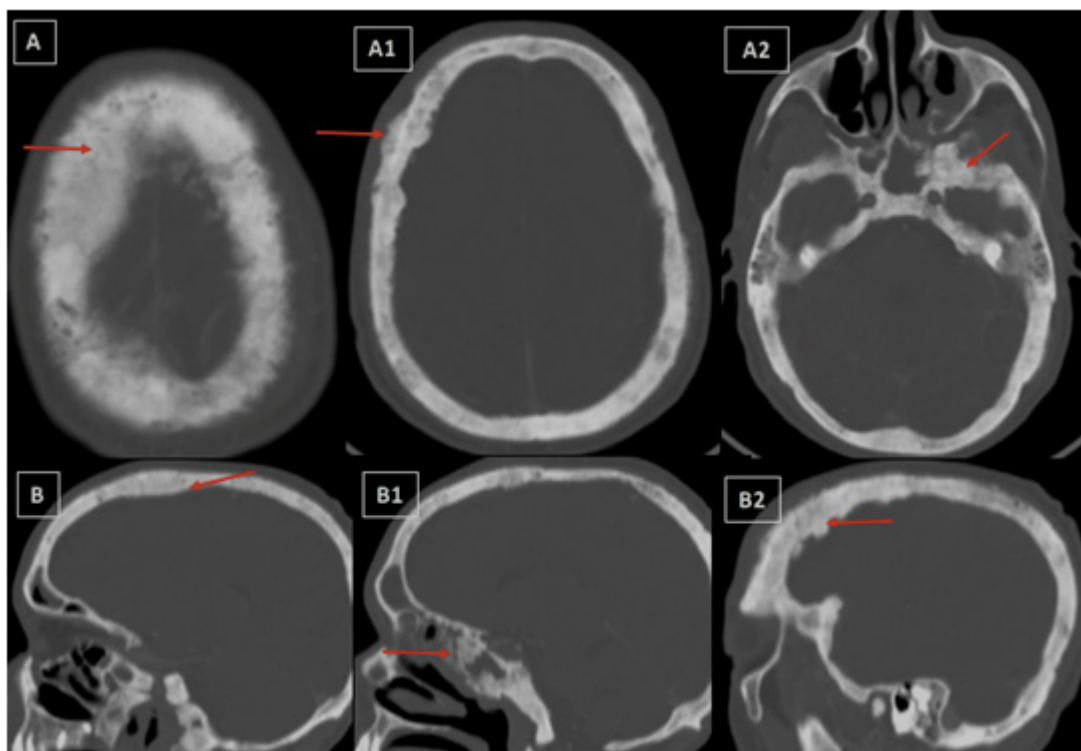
Axial Cerebral bone window CT (A,A1,A2) with sagittal reconstructions (B,B1,B2): Diffuse osteoblastic lesions of the cranial vault and the skull base, irregular bone thickening and loss of differentiation between the inner, outer tables and the spongy bone of the diploë. (Red Arrows).
